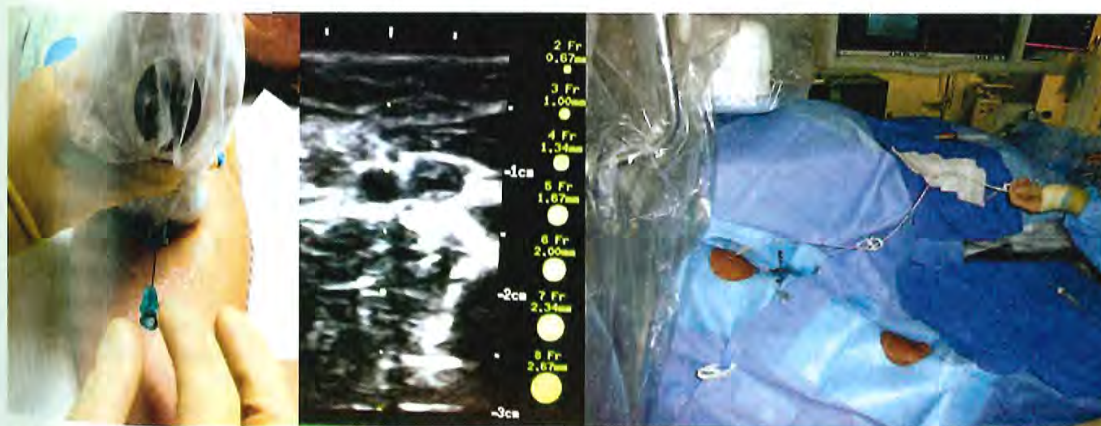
Ultrasound-guided access and setup for brachial venous transradial catheterization.
